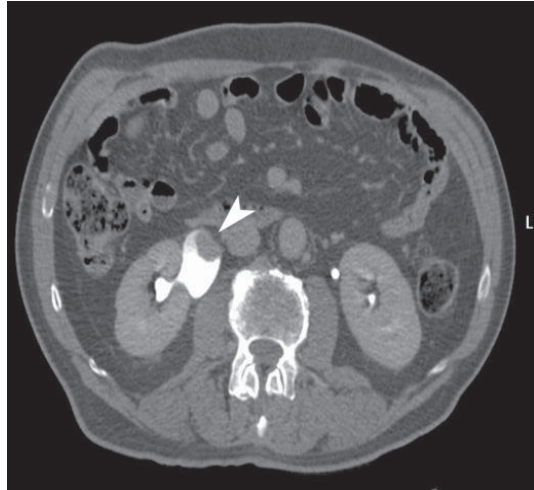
Computed tomography. Transitional cell carcinoma. Same case as Figure 9.63. Solid lesion in the right renal pelvis (*arrowhead*)
